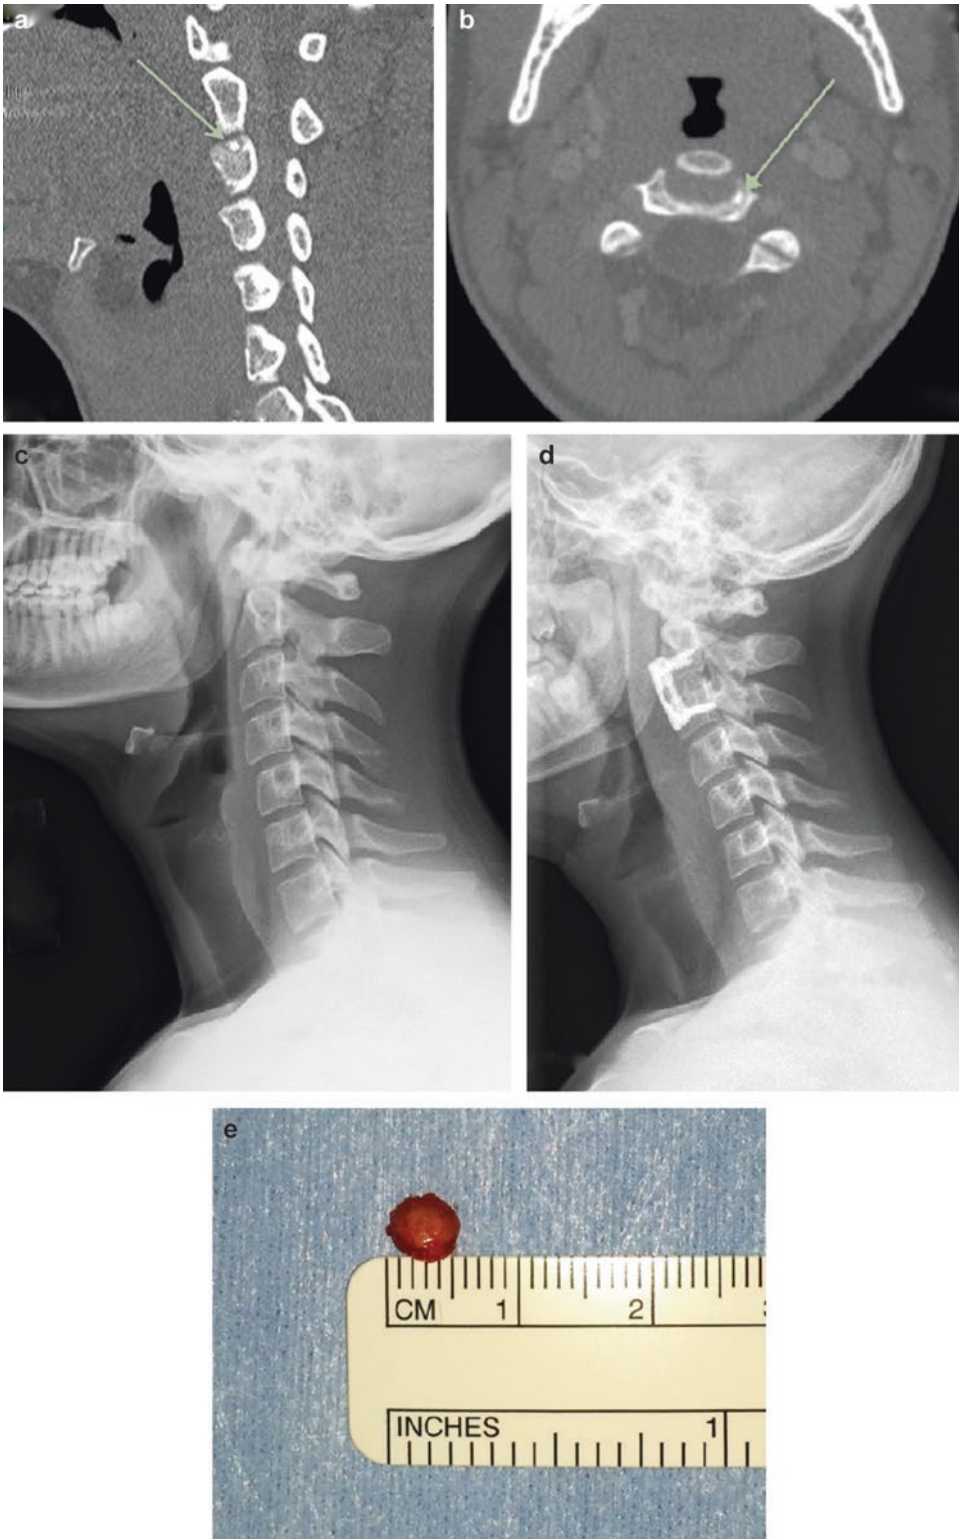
(a–e) Imaging of an adolescent male patient with a diagnosis of symptomatic osteoid osteoma. (a) Sagittal and (b) axial preoperative computed tomography images of the cervical spine show an osteoid osteoma of the C3 vertebral body (see *arrows* on each). (c) Preoperative
